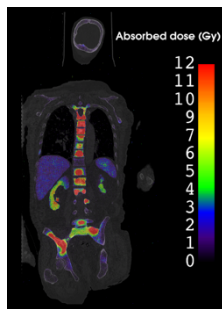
Figure title: Coronal slice of the absorbed dose map for a patient after the first ^{177}Lu -PSMA cycle.
